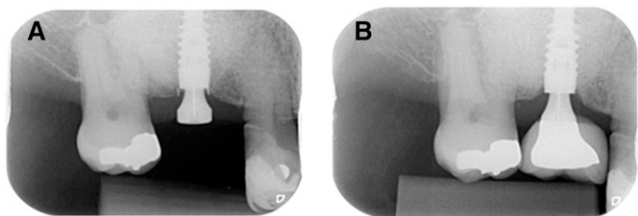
Radiographic measurements at baseline (A) and 2 years after implant was loaded (B).
